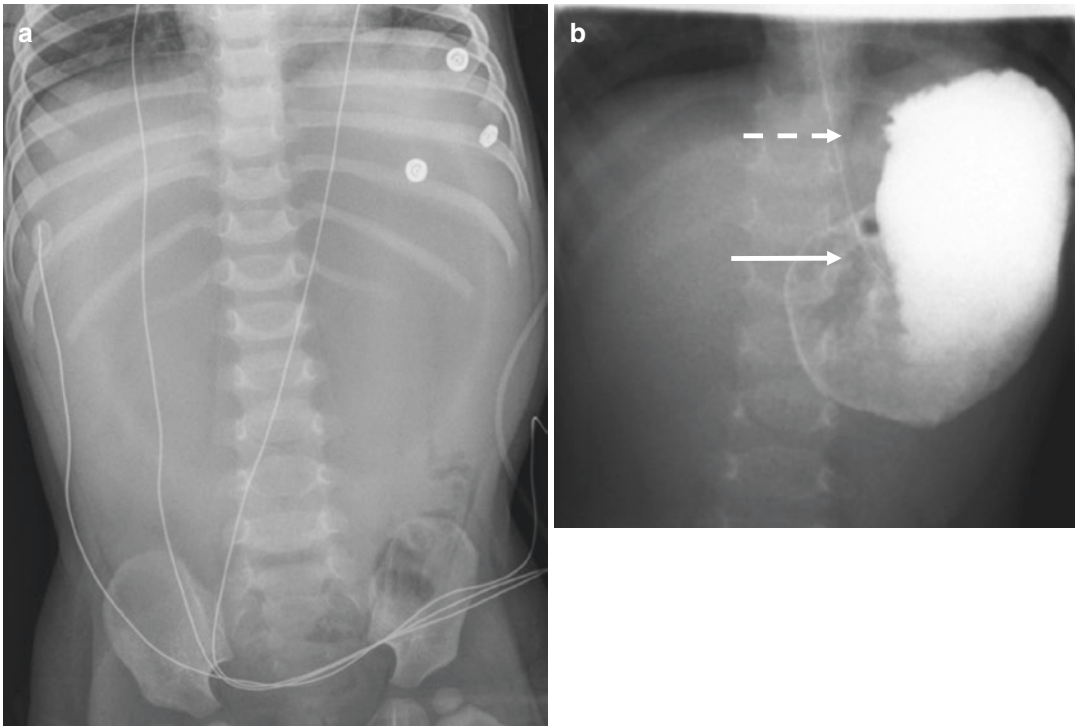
Mesenteroaxial volvulus in a 16-month-old girl with nonbilious vomiting for 48 h and abdominal distension. (a) Supine abdominal radiograph shows a marked spherical distension of the stomach and paucity of distal
